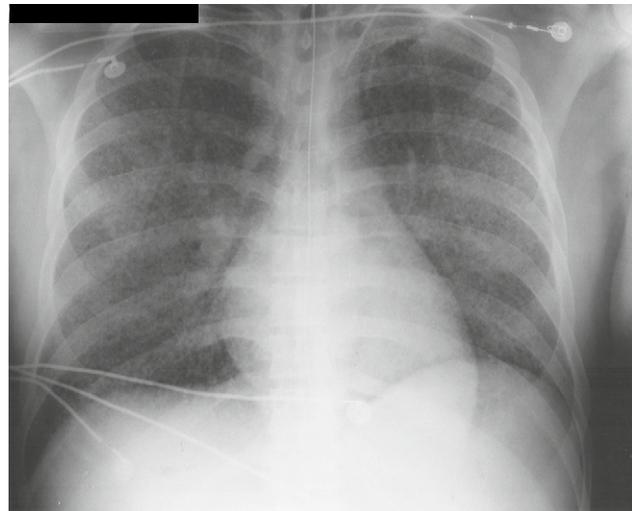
Blastomycosis in a 30-year-old man with septic arthritis of the right knee who developed respiratory distress. AP bedside chest radiograph demonstrates bilateral, generalized miliary nodules without pleural effusion or lymphadenopathy. A feeding tube and left central line are in place. Open lung and skin biopsies demonstrated blastomycosis.
